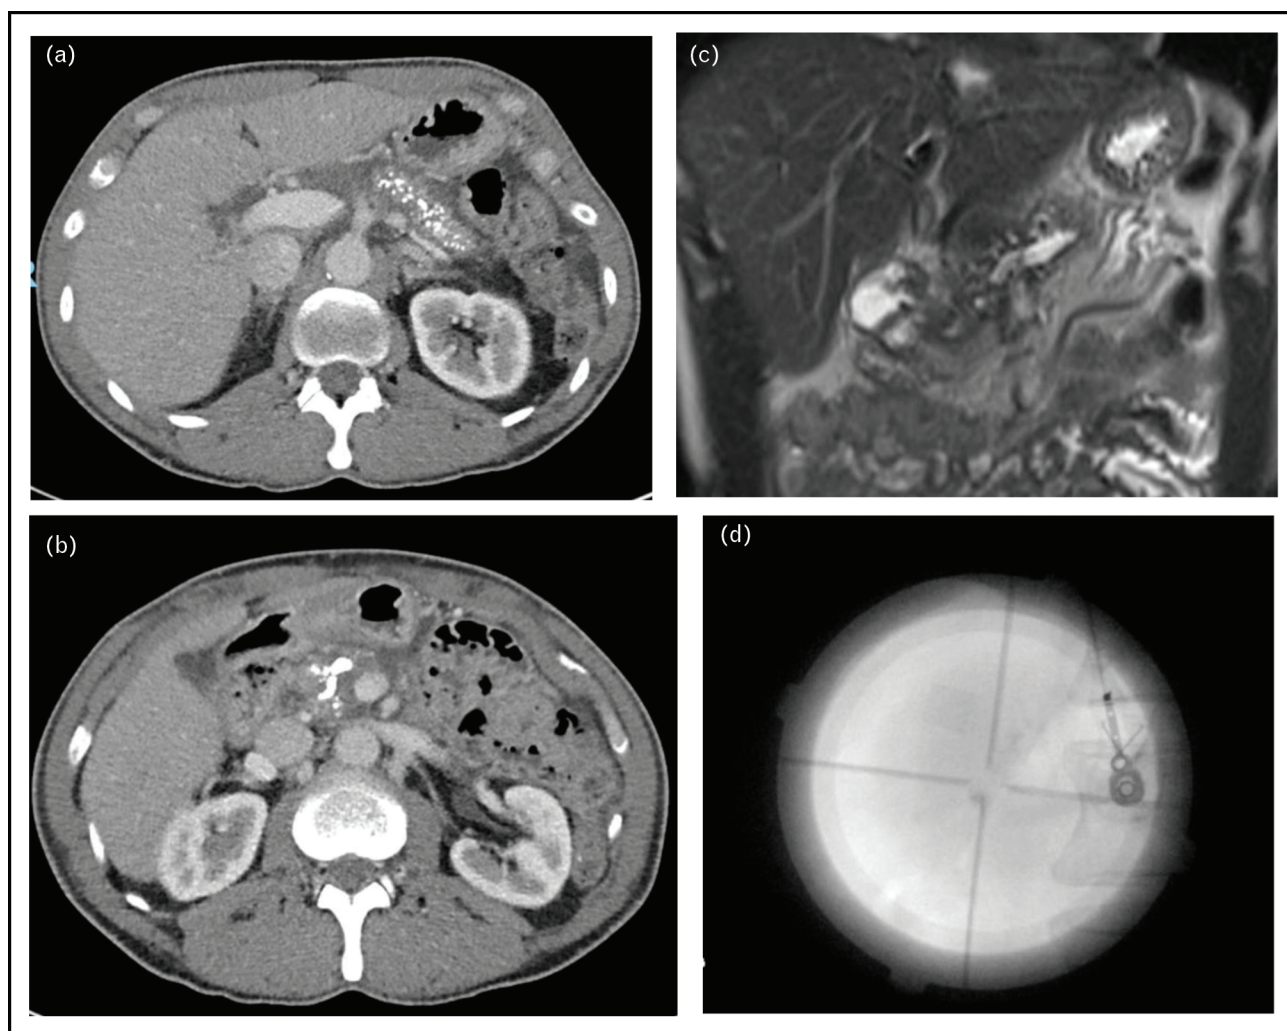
(a) Sagittal computed tomography (CT) revealing numerous pancreatic body and tail parenchymal calcifications in a patient with chronic pancreatitis. (b) Sagittal computed tomography (CT) imaging showing a large calcification/stone in the neck of the pancreas, which obstructs the pancreatic duct. (c) MRI demonstrating upstream dilation of the main pancreatic duct in the body and tail secondary to obstruction by the pancreatic calculus. (d) Fluoroscopy is used to triangulate the calculus and determine a target for energy delivery. Lithotripsy is then performed to fragment the calculus.
